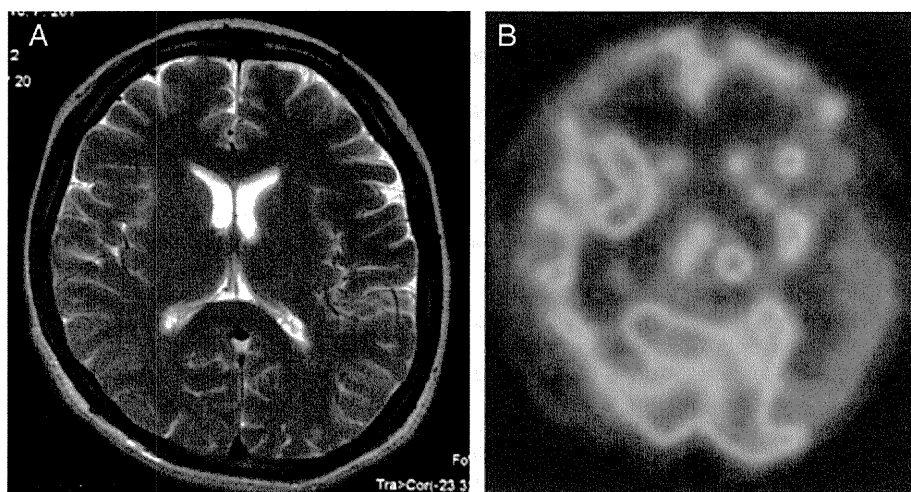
Neuroimaging of the patient. A: T2-weighted magnetic resonance imaging. The frontal lobes show mild atrophy. B: ^{99m}Tc -ECD single photon emission computed tomography. Hypoperfusion over the left cerebral hemisphere and left striatum were noted. Diminished blood flow to the right frontal cortex was also noted.
